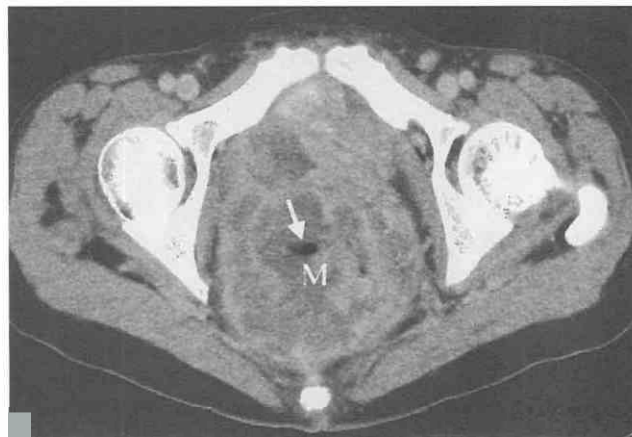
Mucinous adenocarcinoma of the rectum. CT scan shows a large heterogeneous mass (M) with areas of cystic components. Note marked luminal narrowing of the rectum (arrow).
